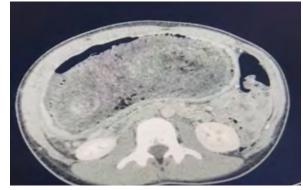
Preoperative CT scan with Gastric cavity occupied by the bezoar
